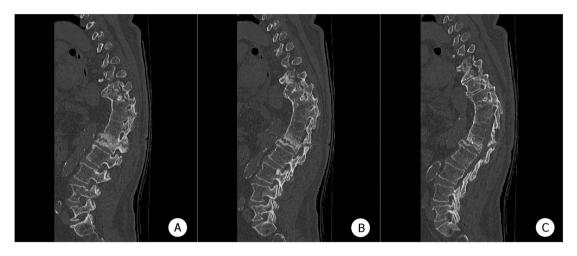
The computed tomography that the patient first visited our hospital.. The fracture line passed through L1 vertebra body and towards the spinous process. This was fracture of fusion mass caused by old healed spinal tuberculosis.
